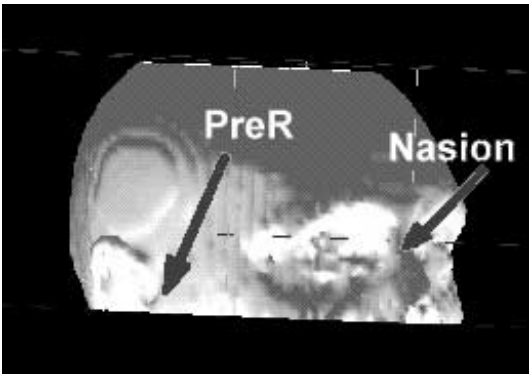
Two landmarks identified on the MRI surface rendering.
